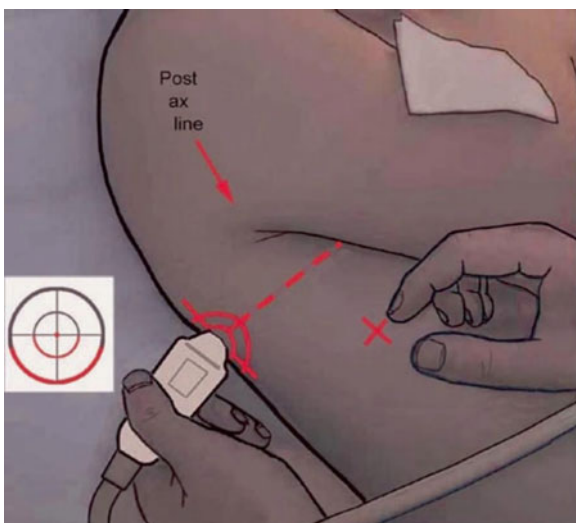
The PLAPS point (PLAPS: posterolateral alveolar and/or pleural syndrome). The probe is applied at the PLAPS point, i.e., the intersection between the transversal line continuing the lower BLUE point (*dotted line*), and the longitudinal posterior axillary line (*arrow*), or, as seen here, as far as possible behind. This will immediately detect small and large pleural effusions (and 90 % of cases of alveolar consolidations in the critically ill patient) (from *Whole Body Ultrasonography in the Critically Ill*, Springer)
